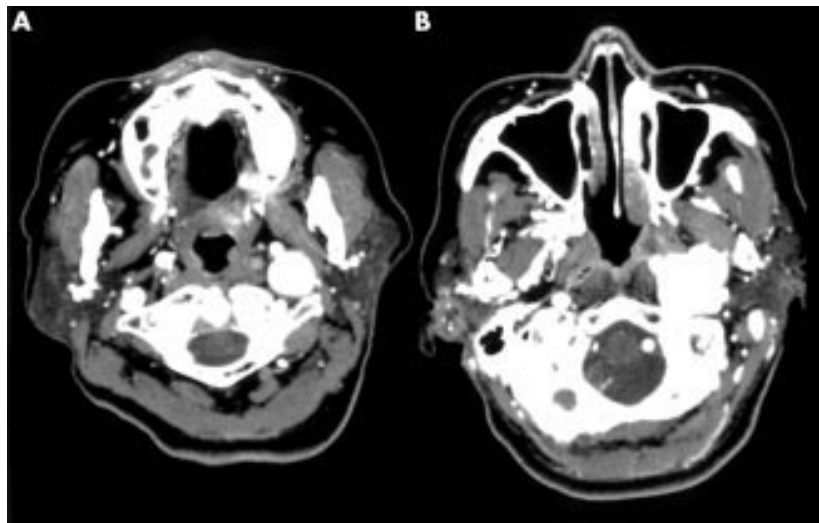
Contrast axial computed tomography scan (A) at the level of the atlas and (B) through the base of the skull. There was a large aneurysm of the extracranial internal carotid artery.
